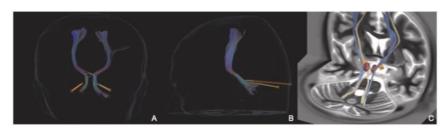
Bilateral deep brain stimulation (DBS) of the dentate nucleus and relation with dentatorubrothalamic tracts (DRTT). Three-dimensional depictions of electrode placement in the dentate nucleus and its relations to the dentate-rubro-thalamic tract (DRTT). Fig. 1A and B result from a co-registration of pre-operative MRI with patient-specific deterministic tractography and post-operative CT (Elements Software, Brainlab AG, Germany). Fig. 1C originates from a co-registration of pre-operative MRI and post-operative CT, however normalized to the MNI space and comparing electrode position with a normalized DRTT projection (LEAD DBS Software, Horn & Kuehn, Germany).
